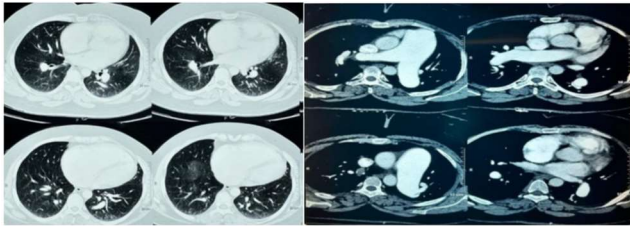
Patient CT findings consistent with the mosaic pattern lung related to pulmonary hypertension, consisting of regions of hypoattenuation due to hypoperfusion interspersed with areas of hypo-attenuation where there is normal or excessive perfusion, dilated pulmonary arteries, and an enlarged right ventricle.
